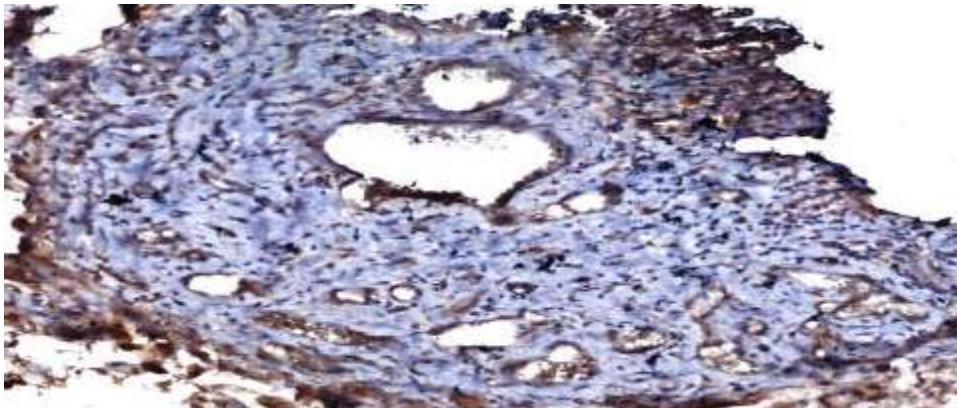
GB showing glomeruloid endothelial proliferation, with cytoplasmic and membranous endothelial cells expression of PSMA, Original magnification power 200x
